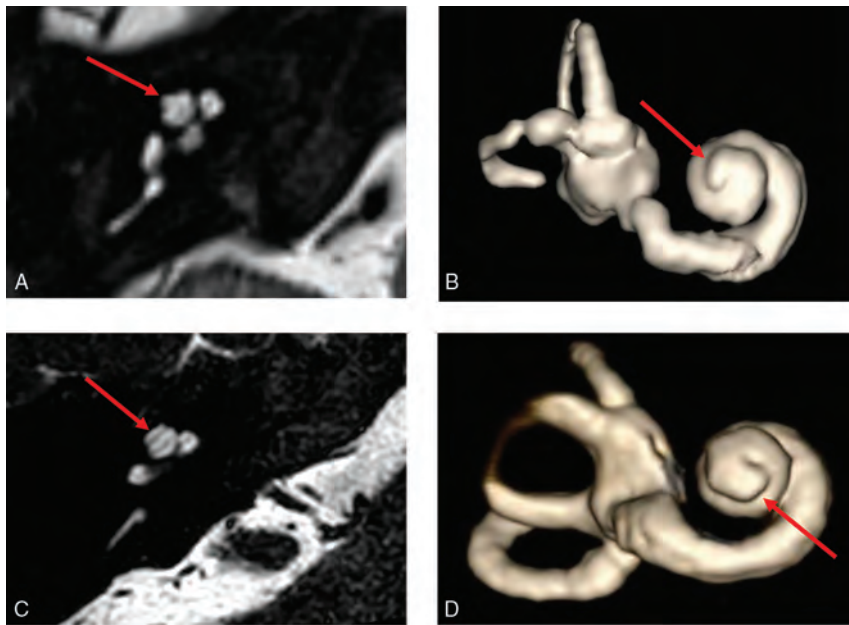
Thorny apical turn of the *SIX1*-BOR cochlea. Axial heavily T2-weighted MR image (A) and 3D reconstruction of the cochlea (B) show a short, thin, protuberant projection forming the apical turn, imparting upon it a thorny morphology (arrows in A and B). Contrast it with the normal apical turn morphology in a patient with normal hearing and no history of BOR or sensorineural hearing loss (C and D), which is longer with a smooth flat appearance and rounded end (arrows in C and D).
